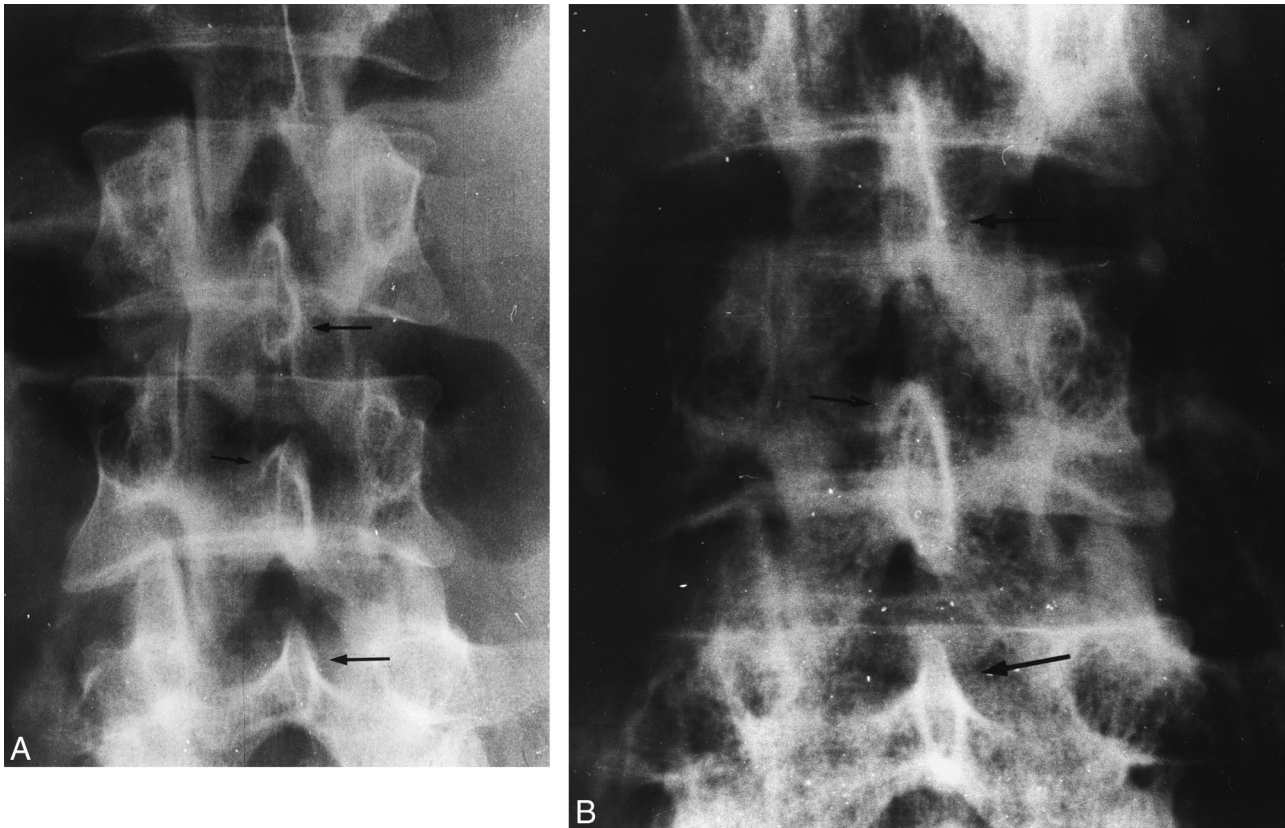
(A) Antemortem radiograph of anteroposterior view of lumbar spine. (B) Postmortem radiograph of anteroposterior view of lumbar spine. Arrows indicate the unique morphologic characteristics of the vertebral processes instrumental in the identification.
